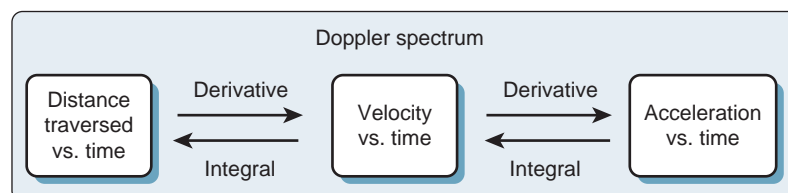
Relationship among distance, velocity, and acceleration. The derivative of the function of position versus time results in its velocity; the derivative of the velocity at any given point would be its acceleration. Similarly, the integral of acceleration is velocity; the integral of velocity is the distance traversed. A Doppler spectrum is displayed a velocity versus time spectrum. If one integrates this spectrum between two time points, that is, calculates the area under the curve, the distance traversed during this period may be calculated.
